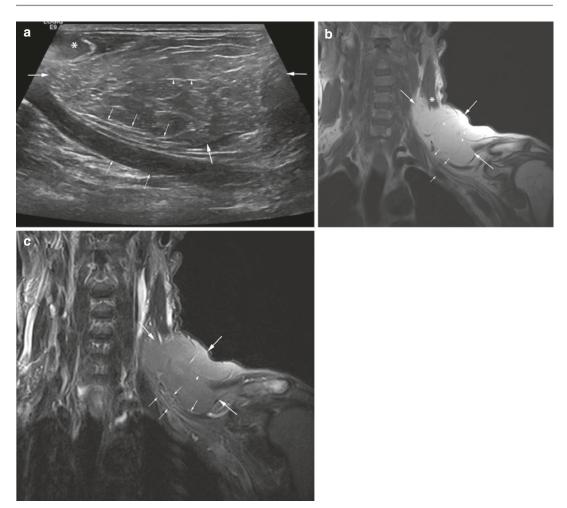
(a–c) Lipoma of the left neck and supraclavicular region with left arm symptoms. (a) Ultrasound. (b) Coronal SE T1-weighted and (c) fat-suppressed T2-weighted MR images. The lipoma is intramuscular and subcutaneous. Ultrasound examination shows a homogenous, hyperechoic mass (*large arrows*) (a). On
